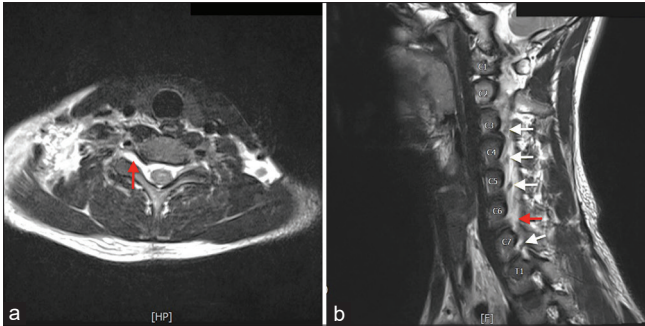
T2 axial (a) and sagittal (b) cervical spinal cord magnetic resonance imaging revealed nonvisualization of neural element in right C6/7 neural foramen (red arrow) suggesting right C7 nerve root avulsion injury with complete tear. White arrow, normal neural elements
